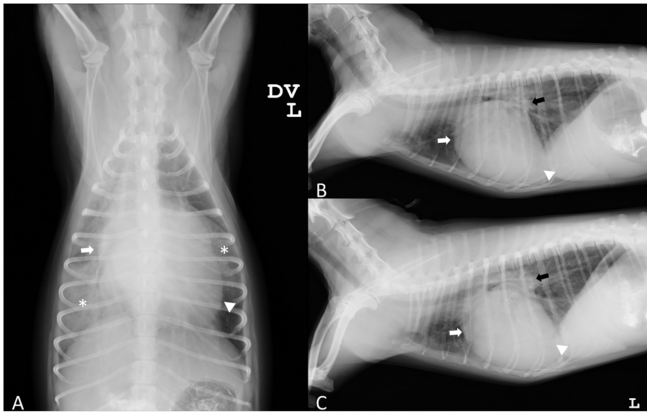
Dorsoventral (A), right lateral (B), and left lateral (C) thoracic radiographs of the patient revealing moderate enlargement of the left ventricle (arrowhead) with mild bulging of the right (white arrow) and left (black arrow) atria. Moderate alveolar pattern (asterisk) in the right lung lobe and cranial part of the left caudal lung lobe are also detected.
